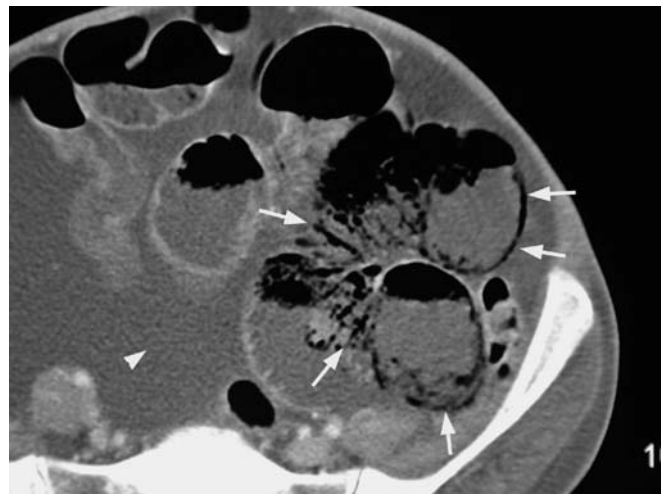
Pneumatosis in small bowel infarction. CT shows multiple linear gaseous inclusions in the wall of multiple small bowel loops (*arrows*). A highly specific finding in bowel ischemia. Note: ascites (*arrowhead*) were related to severe liver cirrhosis in this particular case
